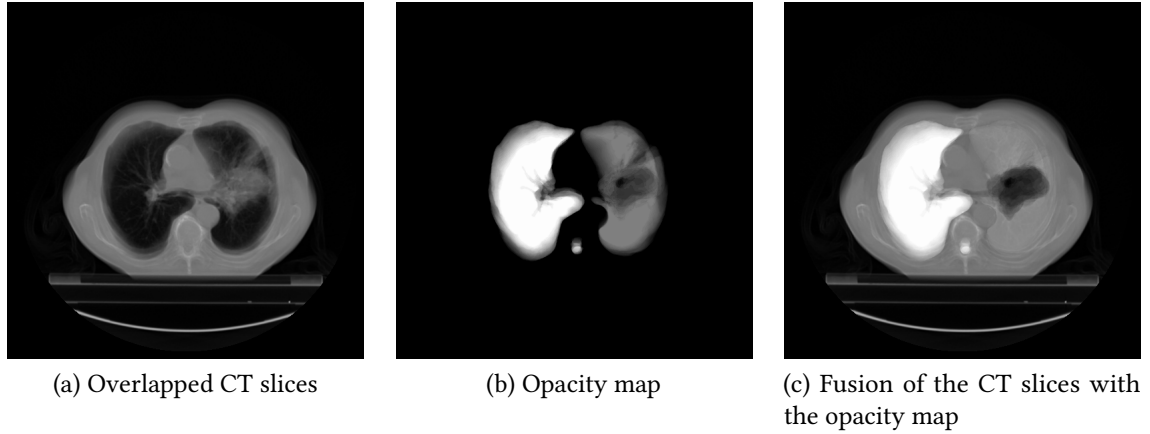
Fusion process where CT slices are blended with the opacity map.
